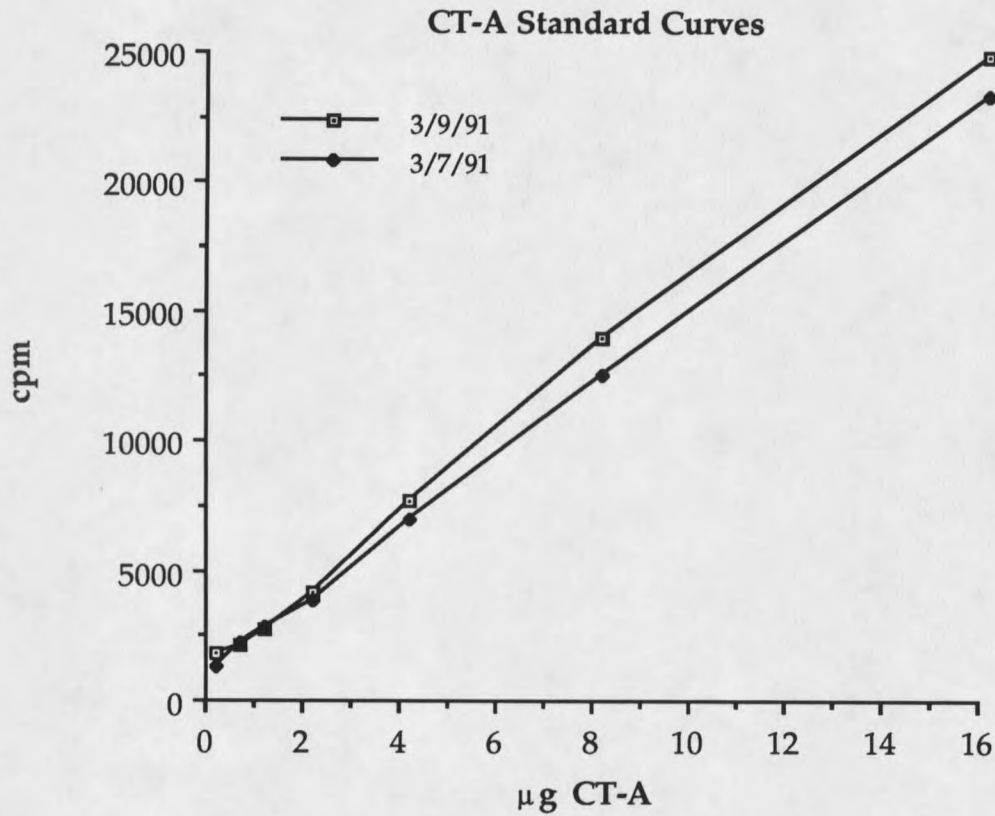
Standard curve of purified CT-A activity as measured by the agmatine assay.
